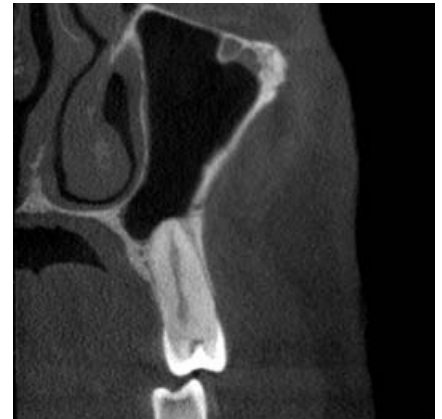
Coronal CBCT image
